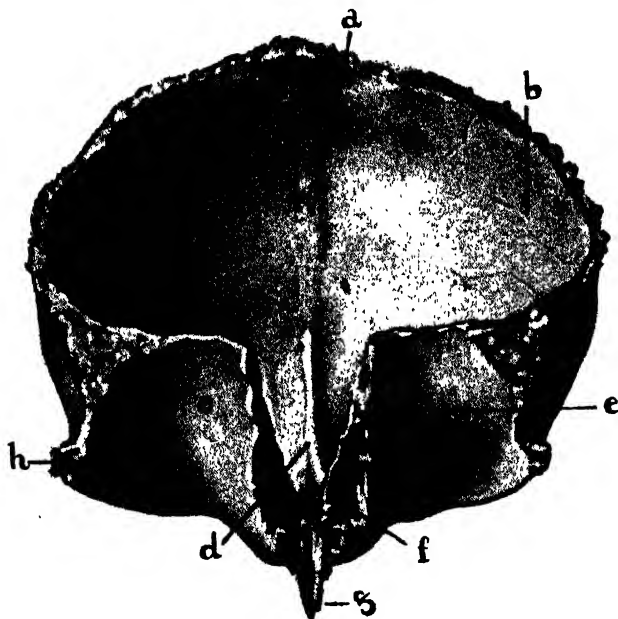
FRONTAL BONE. INTERNAL ASPECT.
